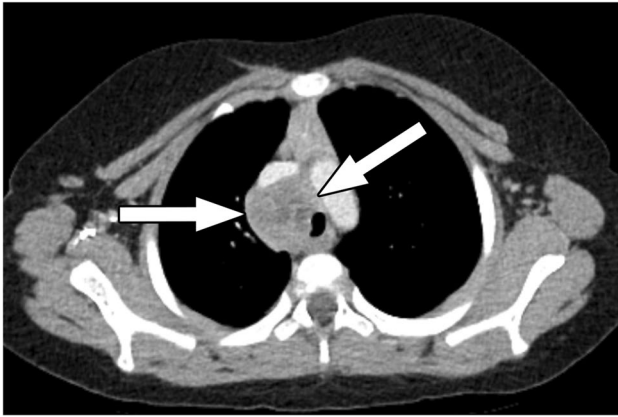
4-year-old girl with active histoplasmosis. Axial chest CT image with IV contrast material shows heterogeneously enhancing right paratracheal lymphadenopathy (arrows). There is mass effect on the superior vena cava anteriorly, and the trachea is deviated to the left. Nodal involvement can be bulky and result in substantial mass-effect
